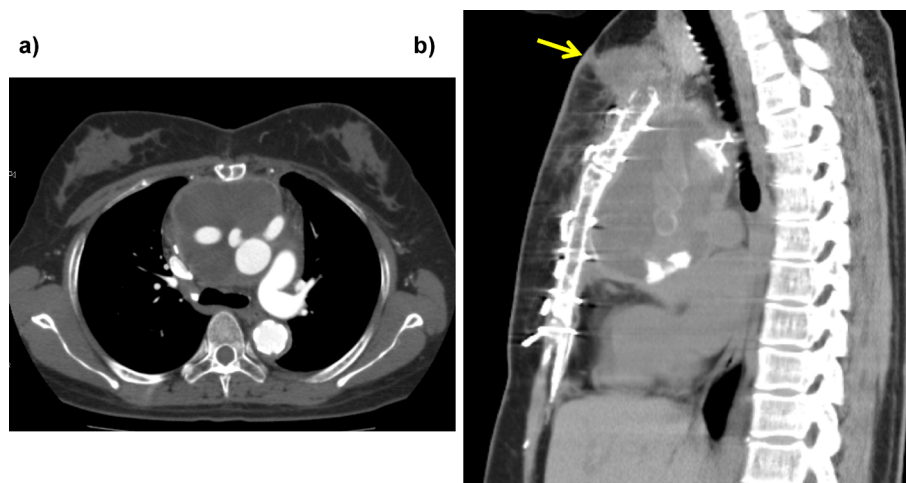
(a) Computed tomography showed a large low-density area around the prosthetic graft (80×60 mm) 4 months postoperatively. (b) The mediastinal mass gradually expanded and was continuous with the newly developed subcutaneous mass 5 months postoperatively (arrow).
